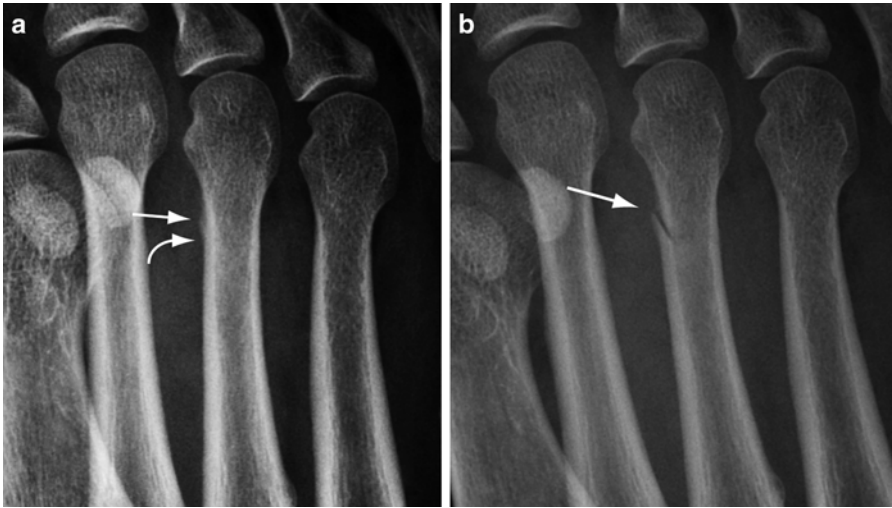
Radiography of early stress fracture. (a) Oblique radiograph of the forefoot shows periostitis of the medial cortex of the third metatarsal shaft (*arrow*) and a subtle
